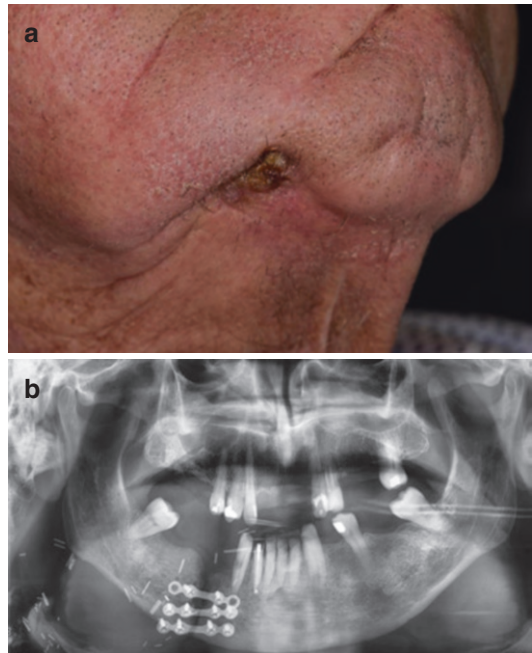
(a) External fistula due to osteoradionecrosis and failure to heal after a tumor resection of a malignant spinocellular carcinoma of the floor of the mouth using a mandibular split osteotomy to gain surgical access. The area of the mandibular split is a predilection place for osteoradionecrosis. (b) Panoramic radiograph
